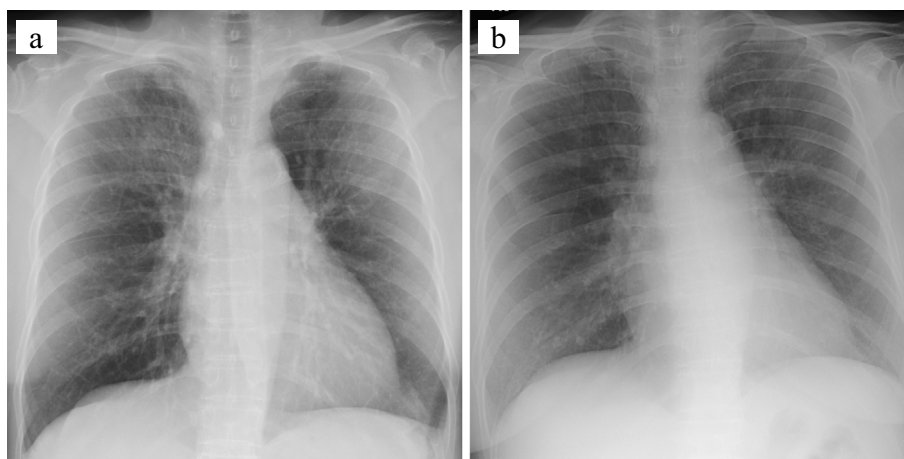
Changes in chest radiographic findings. (a) On admission (7 days after onset), ground-glass opacities (GGOs) were present in the bilateral upper lung fields. (b) On day 12, these GGOs had disappeared in parallel with the improvement in the patient's general condition.
